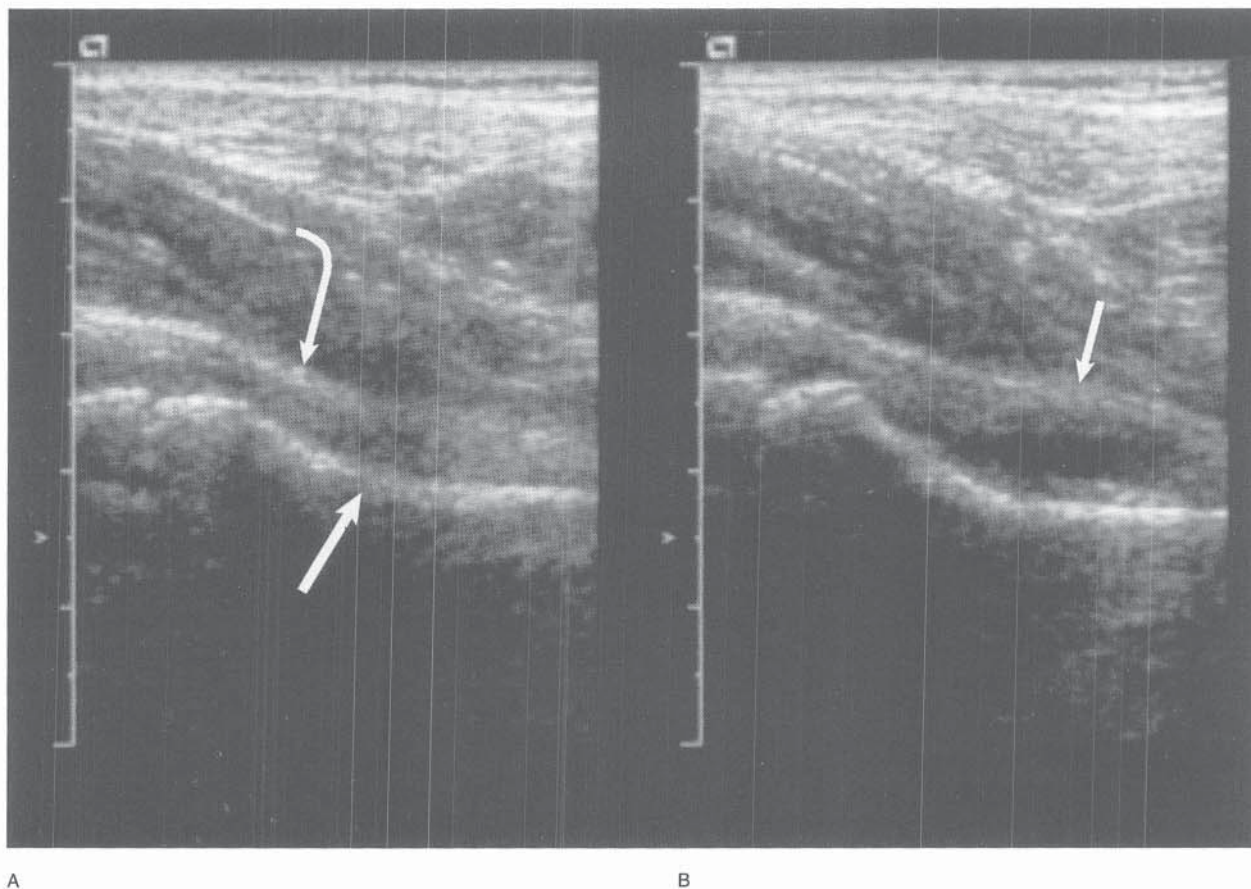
Ultrasound findings in normal and pathologic hip joint capsules. A, Normal hip capsule. The scan was performed anterior to the left femoral neck and demonstrates the echogenic joint capsule paralleling the concave cortical margin. *Straight arrow* points to the cortex; *curved arrow* points to the joint capsule. B, Joint effusion from toxic synovitis. The sonogram shows bowing of the anterior joint capsule with fluid between it and the femoral neck. *Straight arrow* points to the distorted joint capsule.
